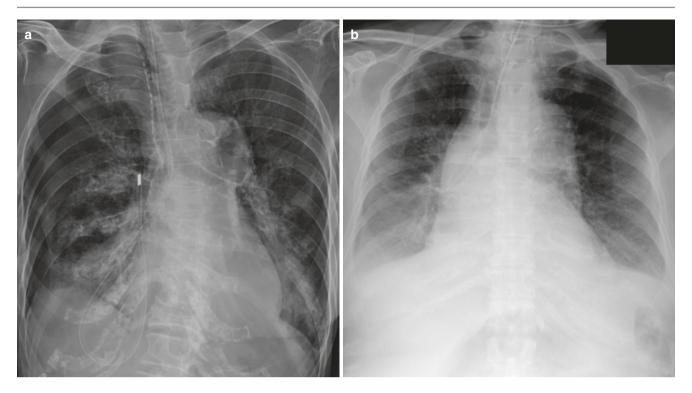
Malpositioned nasogastric tube. (a) AP radiograph shows a nasogastric tube traversing the right main bronchus and coiling in the pleural space with a moderate pneumothorax. (b) AP radiograph in another patient shows feeding tube terminating in the bronchus intermedius
